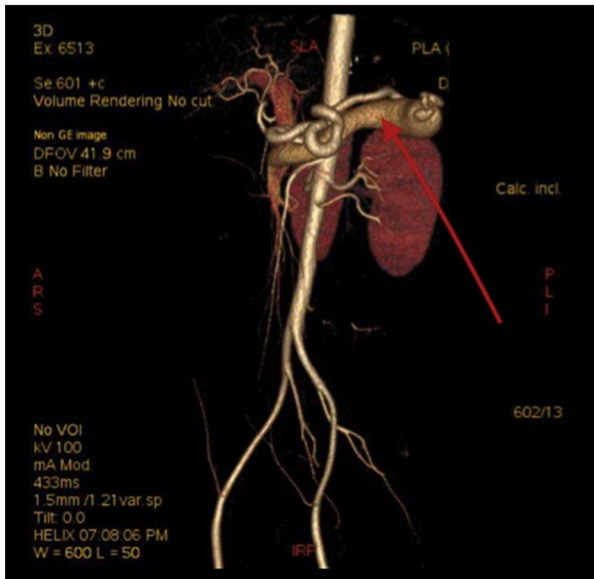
Contrast-enhanced abdominal computed tomography reconstruction shows dilated splenic vein, tortuous splenic vein, and splenic arteriovenous fistula.
